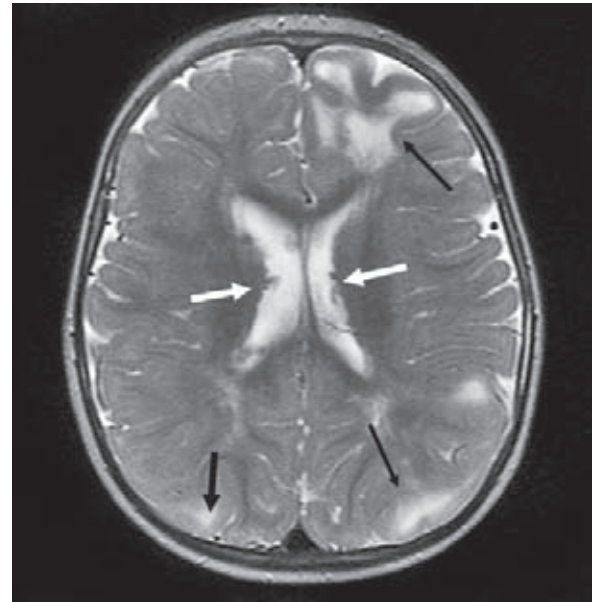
Tuberous sclerosis. Axial T2-weighted MR image shows several subependymal nodules within both lateral ventricles (white arrows). The high signal intensity lesions within the cerebral hemispheres represent cortical tubers (black arrows)
